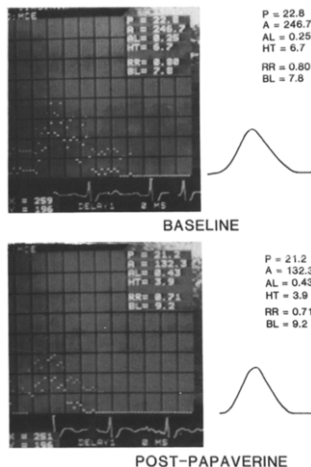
Example of a time-intensity curve at baseline and after papaverine (POST-PAPAVERINE) in a patient with a simultaneous coronary flow reserve of 3.5 determined by intracoronary Doppler probe. After papaverine the half-time (HT) is decreased, the curve width is decreased (corresponding to a higher value for the variable of curve width, AL), the area under the curve (A) is less and corrected peak contrast intensity (P) is unchanged. BL = baseline video intensity; RR = mean RR interval(s) during acquisition of the curve.
